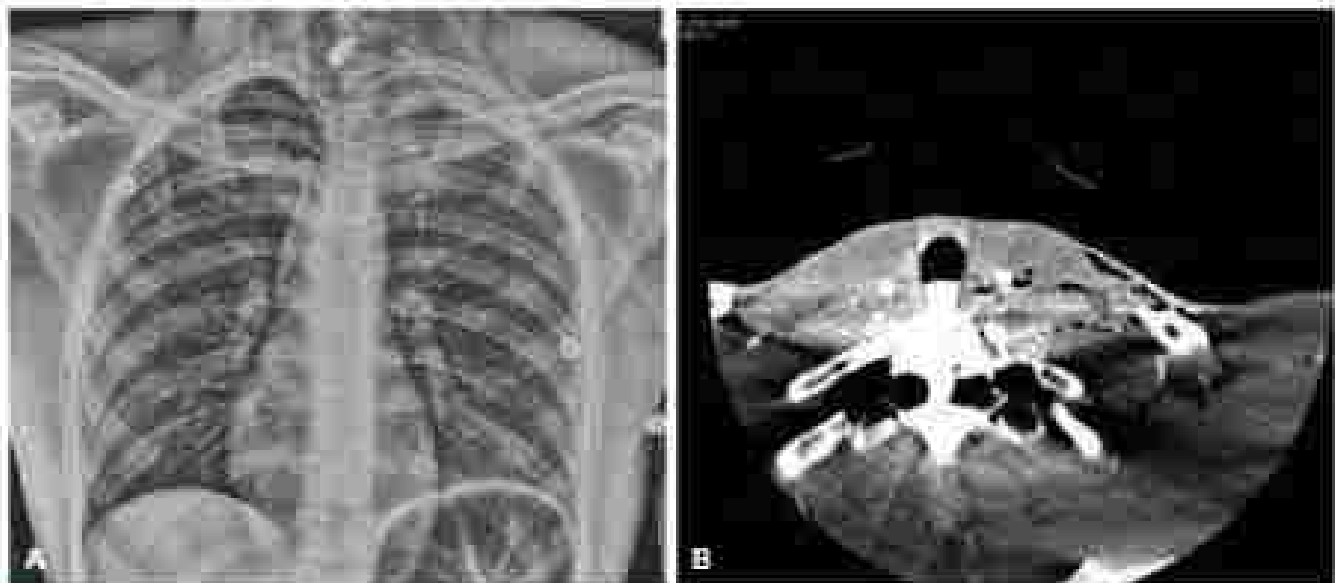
A 24-year-old man presented with a single gunshot wound to the angle of his right jaw. He was hemodynamically normal, with no hard signs of vascular injury. However, he had sensory and motor deficits in his bilateral lower extremities. ... a chest radiograph, the bullet was seen in the proximity of C7-T1 vertebral bodies in the midline. He was objectively examined for airway protection because he was to be kept intubated for further studies. Computed tomography angiogram revealed a bullet lodged in the T1 vertebral canal, possible thoracic aortic trunk injury, and possible right vertebral artery injury. He underwent angiography that demonstrated traumatic occlusion of his thyrocervical trunk. Because of suspicion of neurovascular injury, he underwent further investigation with both esophagoscopy and bronchoscopy. He was found to have a hypopharyngeal injury that was treated with a short course of antibiotics and nasogastric tube decompression. He was extubated on hospital day 2 after a cuff had been demonstrable. A fist was noted on hospital day 2, and the patient was discharged to a rehabilitation facility on hospital day 4.
